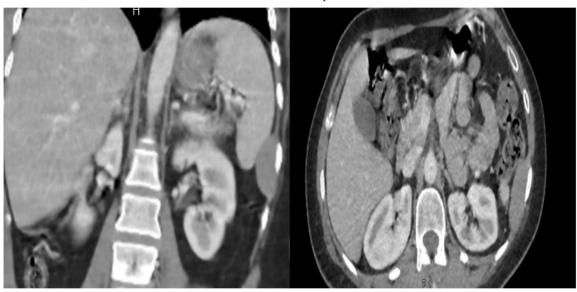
Coronal and axial contrast-enhanced CT scans of the abdomen (portal venous phase, 1-mm slice thickness) showing a well-circumscribed hypodense peri-splenic mass measuring approximately 5.5 x 2 x 5 cm (mean attenuation 65 HU), separated from the spleen by an intact capsule and thin fat plane.
